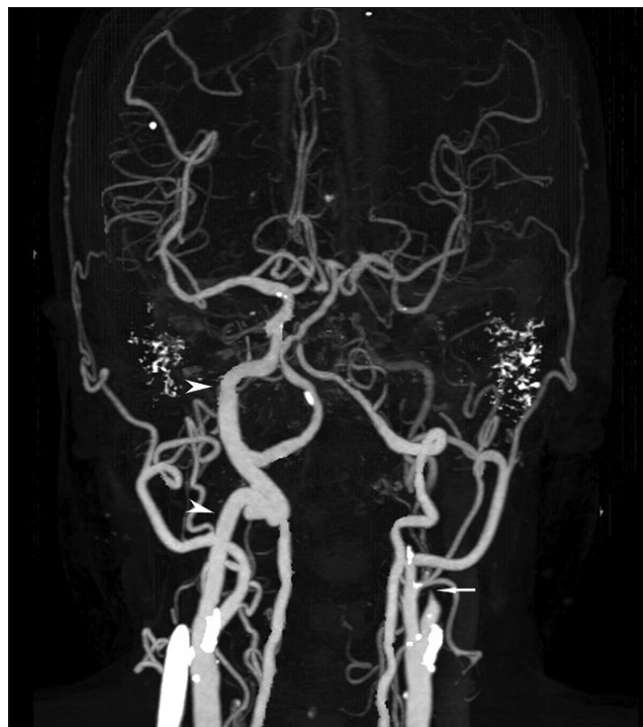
CT angiography demonstrates critical stenosis at left ICA (arrow). There are compensatory flows from right ICA (arrowhead) and bilateral vertebral arteries to maintain an adequate intracranial circulation, but hemodynamic insufficiency is noted in left cerebrum. CT = Computed tomography, ICA = Internal carotid artery
